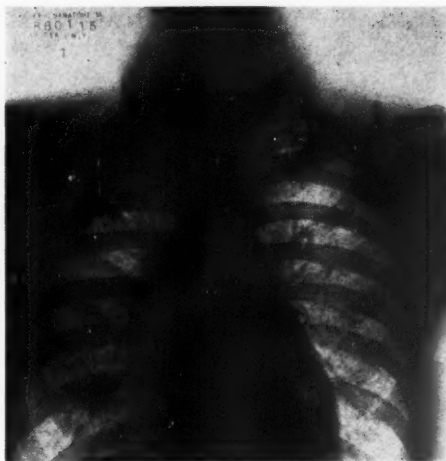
Discharge examination: physical signs—right lung, impaired note to clavicle and 3 V.S., no râles. X-ray findings—right lung, increase in size of cavity.
